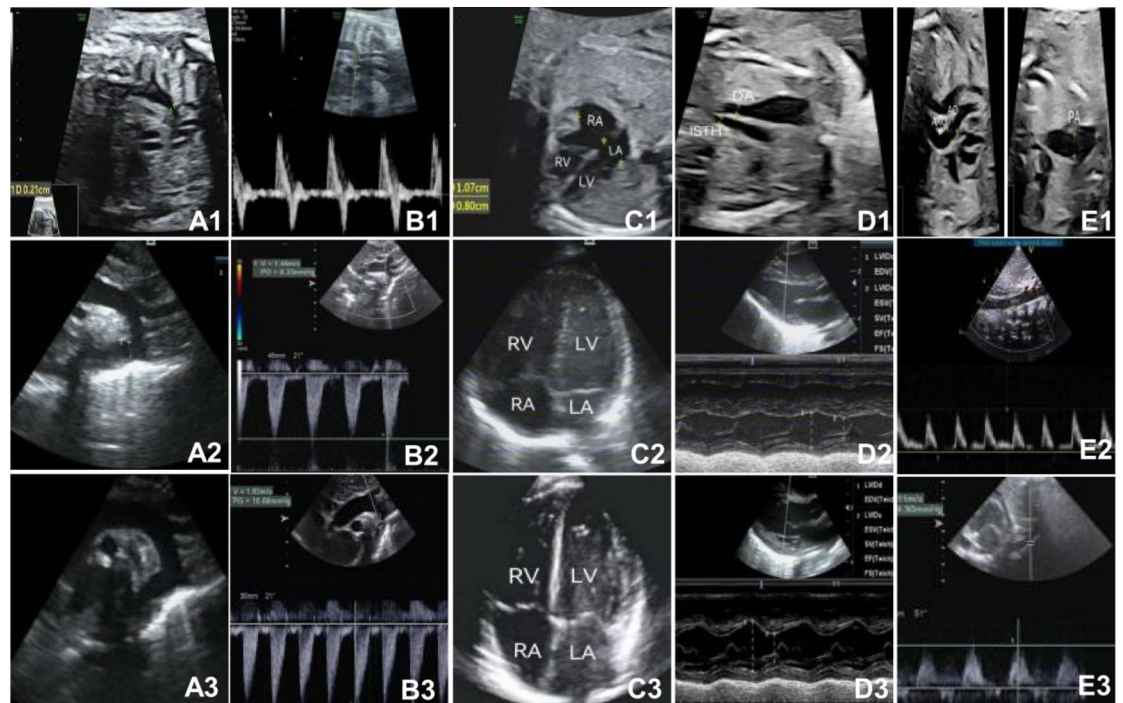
A baby with false-positive coarctation of the aorta (CoA) before and after birth. (A1–E1) Ultrasound images of a fetus at the gestational age 25 weeks and 6 days after birth. (A1) In the aortic arch long axis section, a slightly thinner aortic isthmus was shown with an inner diameter of 0.21 cm (Z-Score: -2.92). (B1) The isthmic blood flow spectrum showed a retrograde flow in the late systole and early diastole. (C1) The right heart ratio was slightly larger, with the left atrial transverse diameter of 0.80 cm and right atrial transverse diameter of 1.07 cm. (D1) In the three vessel tracheal section, the isthmus inner diameter was 0.20 cm, and the inner diameter of the ductus arteriosus (DA) was 0.26 cm. (E1) The ratio of the pulmonary valve annulus diameter to the aortic valve annulus diameter was increased, with the aortic diameter of 0.34 cm (left) and pulmonary artery 0.53 cm (right). (A2–E2) Ultrasound images 31 h after birth without closure of the DA were shown. (A2) The shape of the aortic arch was normal, with an aortic isthmus inner diameter of 0.33 cm. (B2) The isthmic blood flow spectrum and velocity were normal with the peak systolic velocity (PSV) 1.44 m/s and a pressure difference 8.33 mmHg. (C2) The right heart was slightly larger. (D2) The left ventricular systolic function was normal with an ejection fraction (EF) 77.0% and fraction of shortening (FS) 42.2%. (E2) The abdominal aortic spectrum and velocity were normal with a PSV 0.65 m/s. (A3–E3) Ultrasound images 19 days and 8 h after birth with closure of the DA were demonstrated. (A3) The morphology of the aortic arch was regular, with an increase in the inner diameter of the aortic isthmus. (B3) The blood flow spectrum and velocity in the aortic isthmus were normal with a PSV of 1.63 m/s and a pressure difference of 10.68 mmHg. (C3) The size and ratio of the atria and ventricles in the four chamber view were normal. (D3) The left ventricular systolic function was normal with an EF 77.9% and FS 43.6%. (E3) The abdominal aortic spectrum and velocity were normal with a PSV of 1.11 m/s. LA left atrium, LV left ventricle, RA right atrium, RV right ventricle, DA ductus arteriosus, ISTH isthmus, AO aorta, AAO ascending aorta, PA pulmonary artery.
